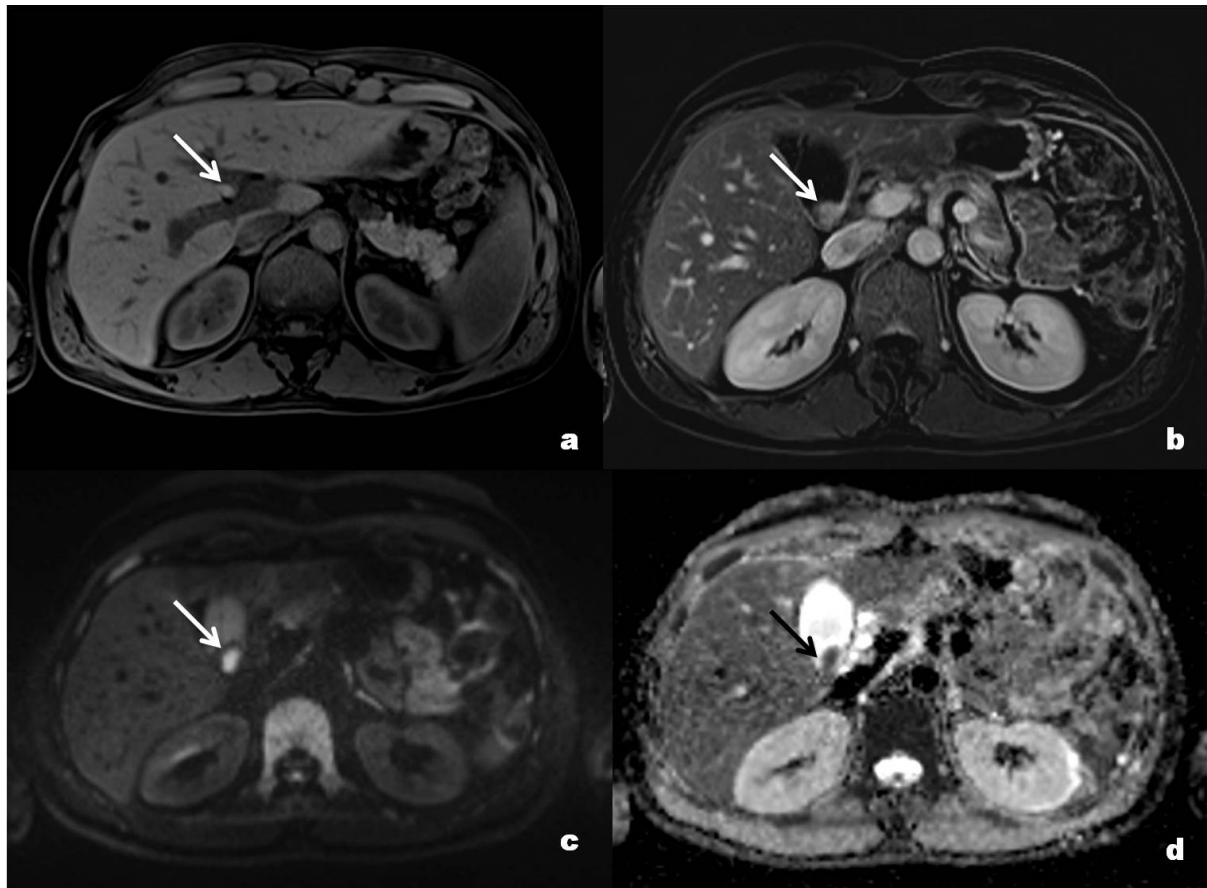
MRI shows vegetating nodular lesion with lobulated contours, based on implantation in the gallbladder infundibulum showing (a) internal hypersignal areas in T1, (b) heterogeneous contrast enhancement, (c) restricted diffusion on DWI with (d) a low ADC value.
